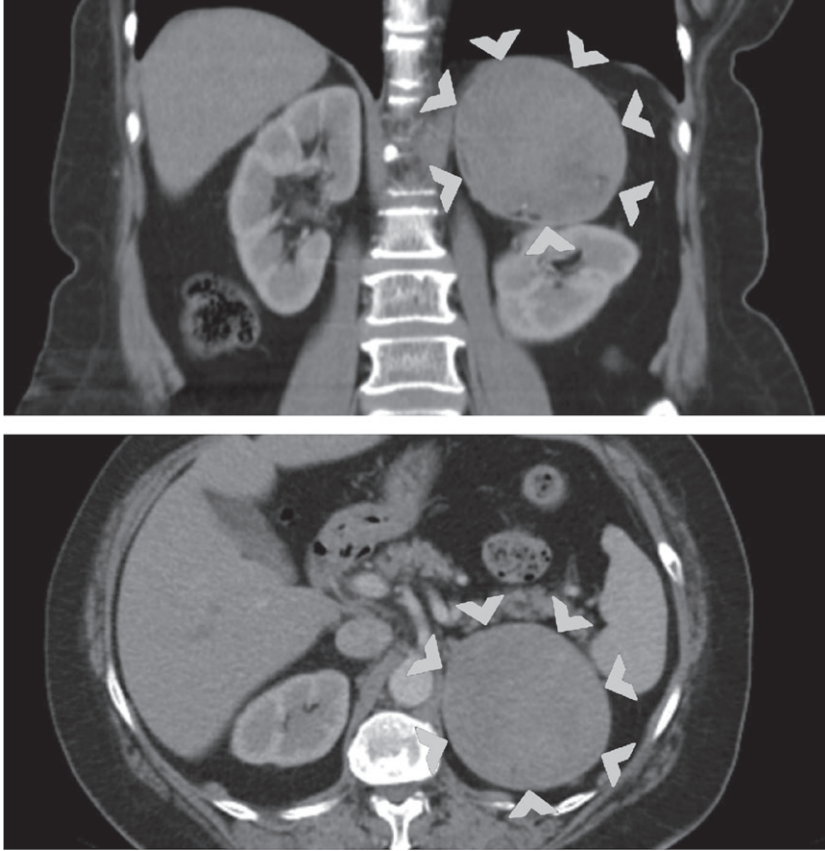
Axial and sagittal computed tomography section of 95×68 mm heterogeneous, spherical-shaped mass lesion in the left adrenal gland with smooth borders.
